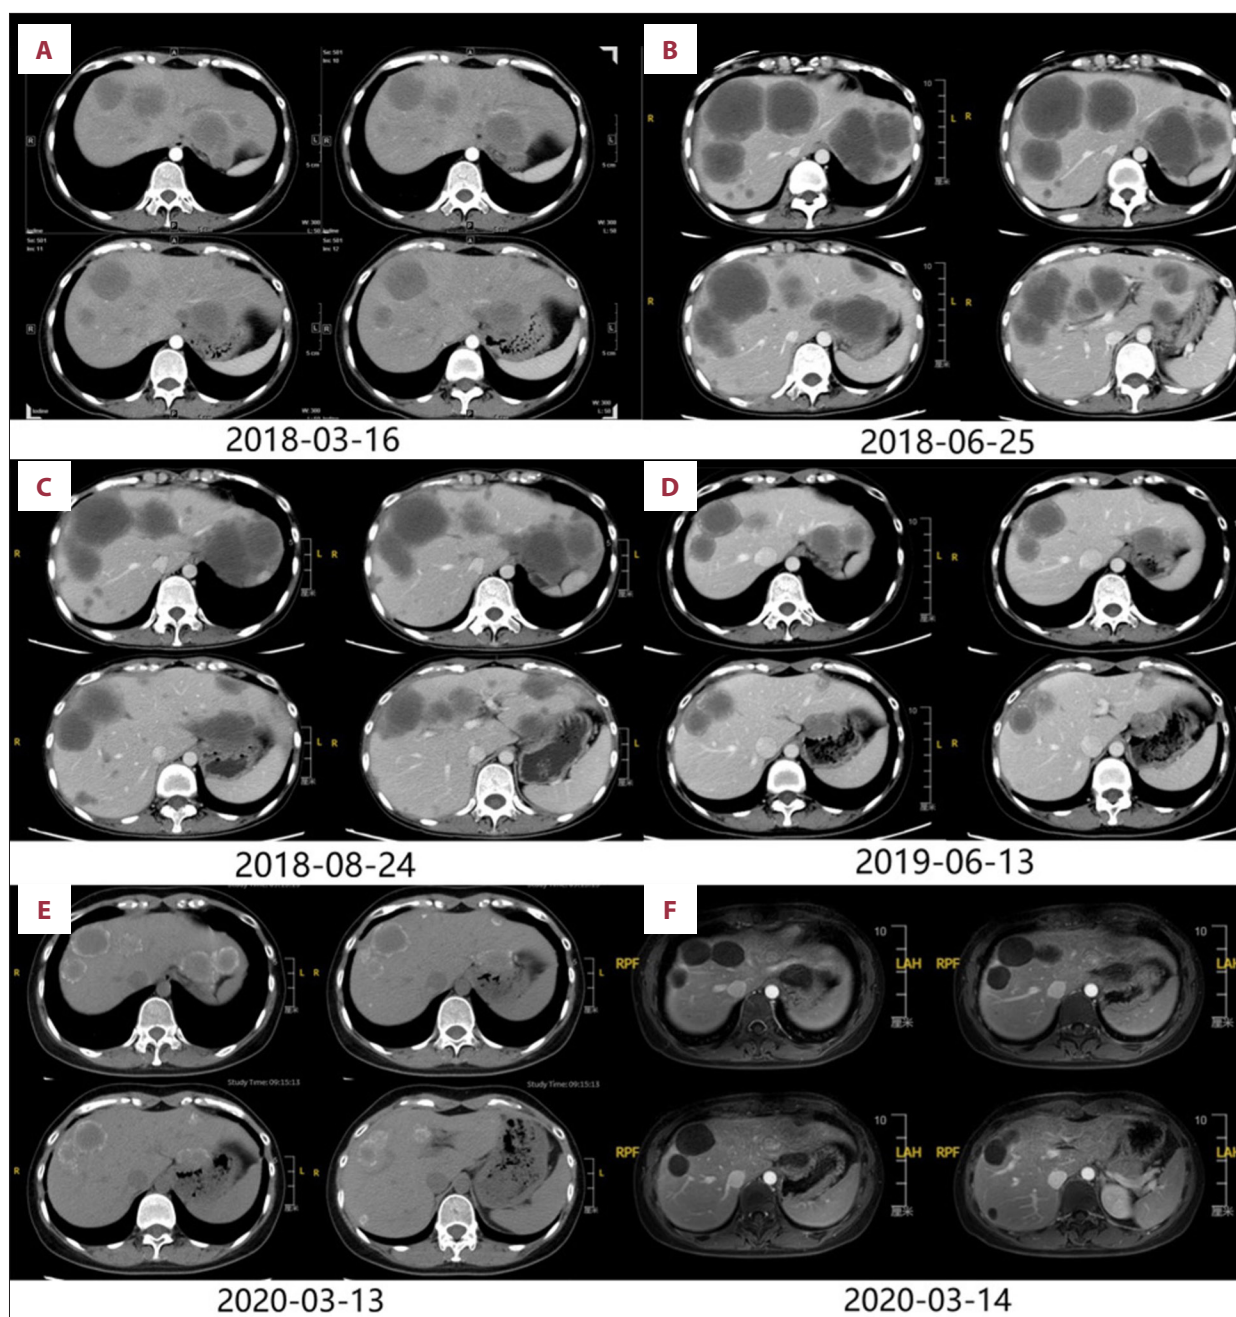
(A-E) Contrast-enhanced computed tomography (CT) showing multiple liver metastases at different times: (A) baseline (2018-03-16); (B) after first-line treatment (2018-06-25); (C) after 2 courses of second-line treatment (2018-08-24); (D) after about 1 year of second-line treatment (2019-06-13); (E) CT before liver tumor resection (2020-03-13); and (F) contrast-enhanced magnetic resonance imaging showing multiple liver metastases (2020-03-14).
